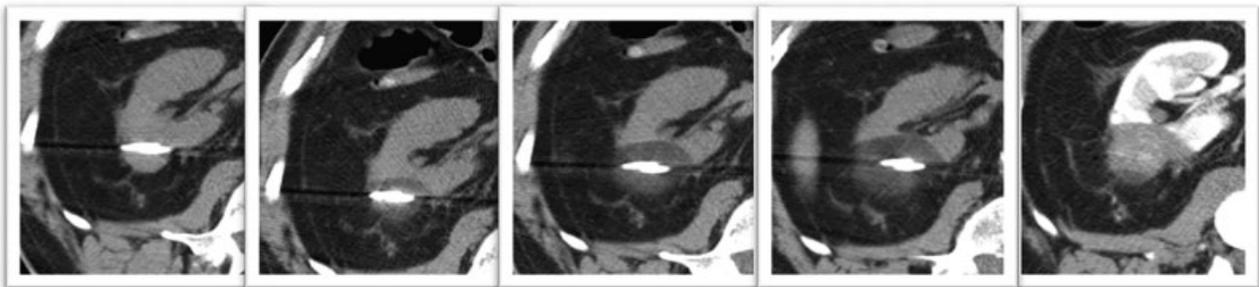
Cryoablation of clear cell renal cell carcinoma (RCC) in a 71-year-old woman: unenhanced CT with cryoprobes in a posterior RCC lesion at 0, 1, 3, and 6 minutes during cryoablation, and contrast-enhanced scan postablation. The ice ball is growing over time. Postablation zone of ablation is avascular.
